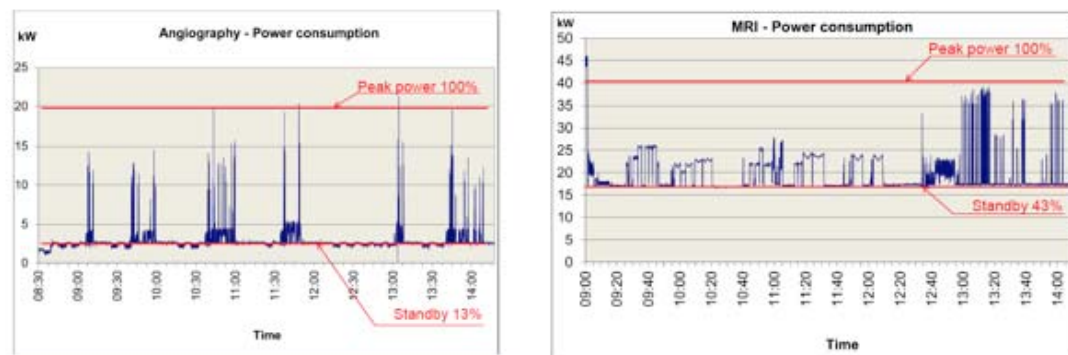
Energy consumption profile of MRI scanners (Source: SINTEF, Norway)
